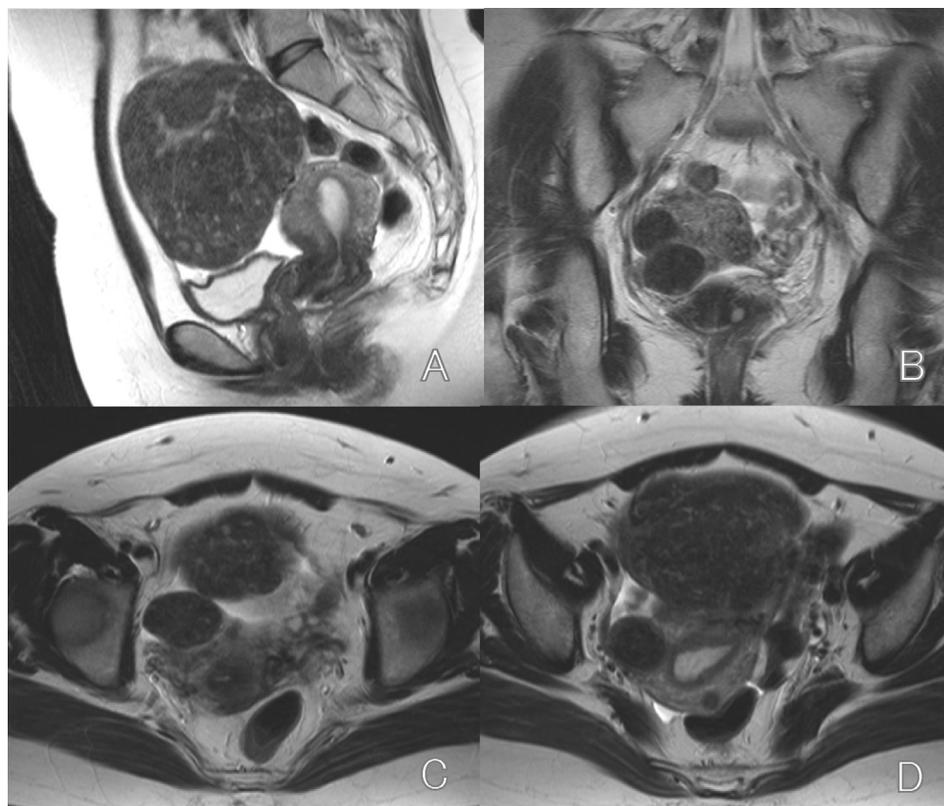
Magnetic resonance imaging (MRI) of uterine myomas. MRI revealed 4 uterine myomas: 1) a subserosal myoma (10 cm in diameter) arising from the uterine fundus (A), 2) a subserosal myoma (3.5 cm in diameter) arising from the center of the anterior wall (B, C), 3) an intramural myoma (2.5 cm in diameter) located on the right side of the anterior wall (B, D), and 4) a small intramural myoma in the posterior uterine body (D).
